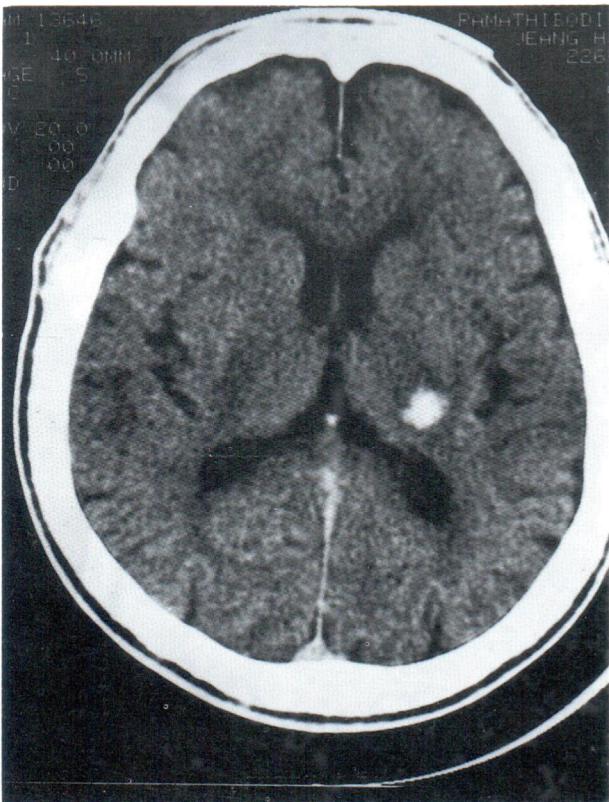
CT shows small hematoma at left internal capsule
